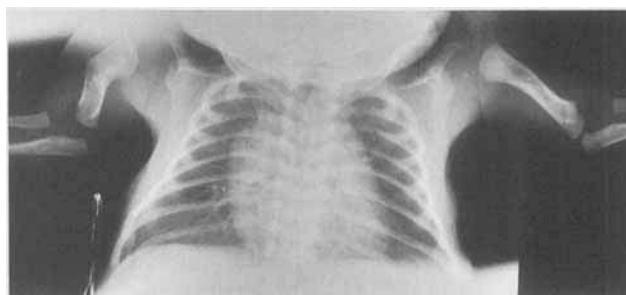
Roentgenogram of chest and arms at birth with rhizomelic shortness and abnormal appearance of humeri. Note stippling of left humerus.
